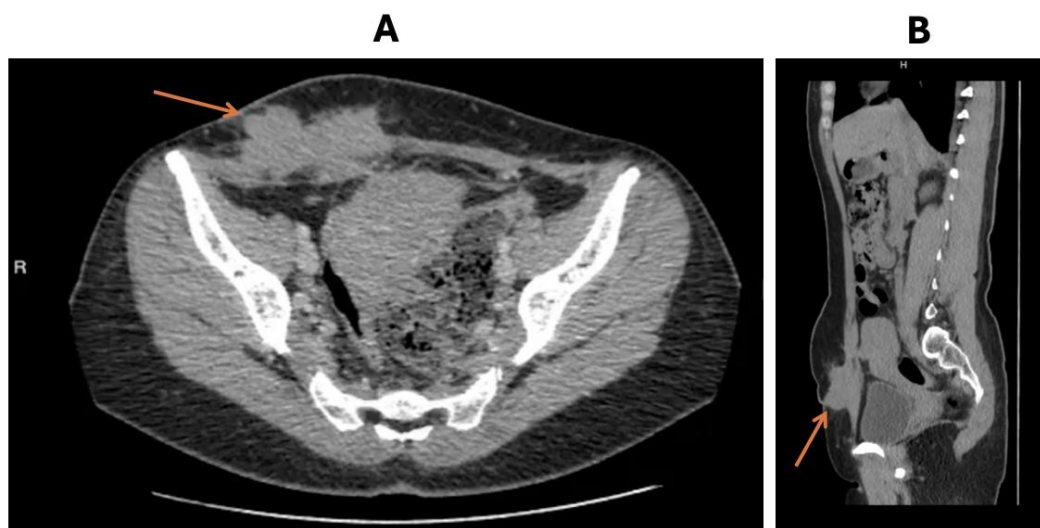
Axial (A) and sagittal (B) CT images demonstrating a soft tissue mass ($8.6 \times 3.2 \times 3.9$ cm) arising from the right rectus abdominis and extending into suprapubic subcutaneous fat.
